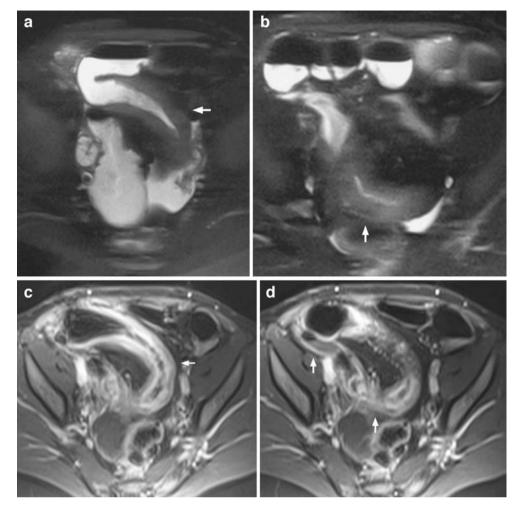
A 14-year-old child with CD. MRI. a, b Axial single-shot fast spin-echo T2-W images (EXPRESS) show stenosis and wall thickening of the distal ileum (*arrows*) with preceding dilatation of the prestenotic segment. c, d Axial RF spoiled FAST contrast-enhanced images. The distal ileum shows wall thickening with stratified contrast enhancement (*arrows*); the mucosa of the bowel wall enhances more strongly than the other layers
